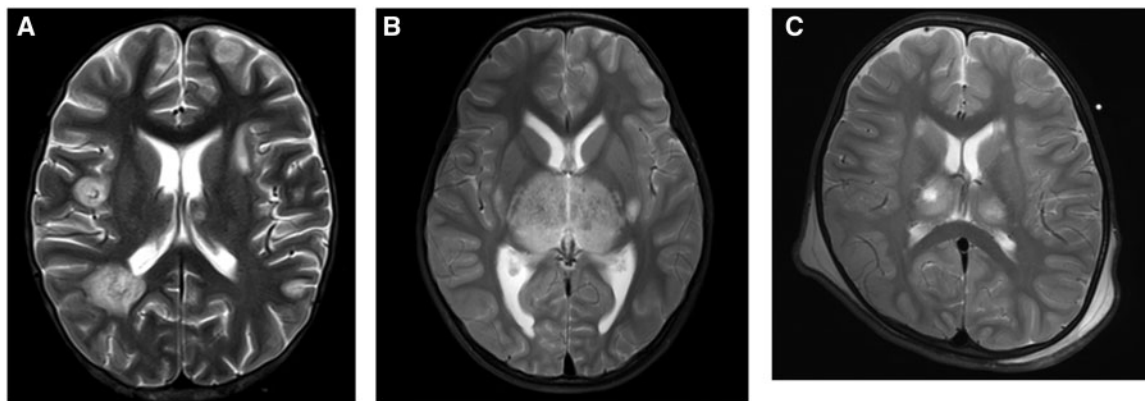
Magnetic resonance imaging images of the brain of three children with H1N1 encephalopathy. (A) An 11-year-old boy (case 1) with acute lymphoblastic leukaemia with no evidence of central nervous system disease; T2W axial image of the brain shows multiple rounded hyper-intense lesions in both grey and white matter of bilateral cerebral hemispheres with hypo-intense foci within (bleeds) suggestive of acute haemorrhagic leukoencephalopathy. (B) A previously well 4-year-old girl (case 2) whose T2W axial image of the brain shows bilaterally swollen thalami and posterior putamen with long TR hyper-intensities and multiple hypo-intense foci within (bleeds) suggestive of haemorrhagic viral encephalitis. (C) A previously well 4-year-old boy (case 6) whose T2W axial image of brain shows multiple rounded hyper-intense lesions in bilateral internal capsules, basal ganglia and thalami with cystic areas within suggesting viral encephalitis.
